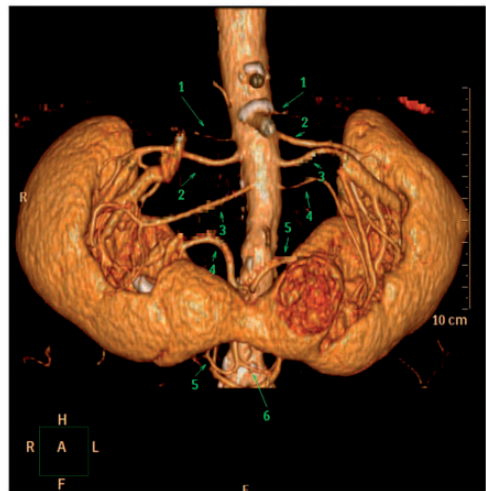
Preoperative computed tomography of the renal artery reveals six artery branches for the left kidney. The fifth and sixth branches are the main supply for the tumor.
